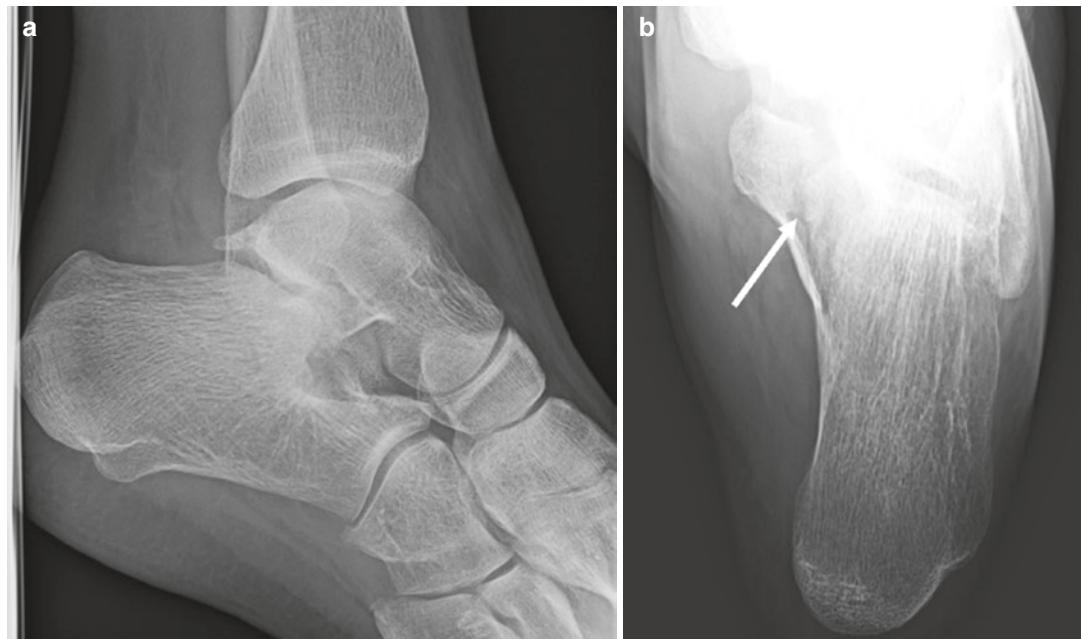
Twenty-two-year-old woman with non-displaced fracture of the calcaneus involving the sustentaculum tali. Lateral radiograph (a) from ankle series
